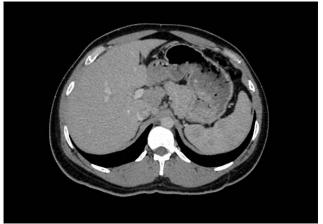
Contrast enhanced CT (axial view) showing multiple ill-defined hypodense lesions in the spleen.
